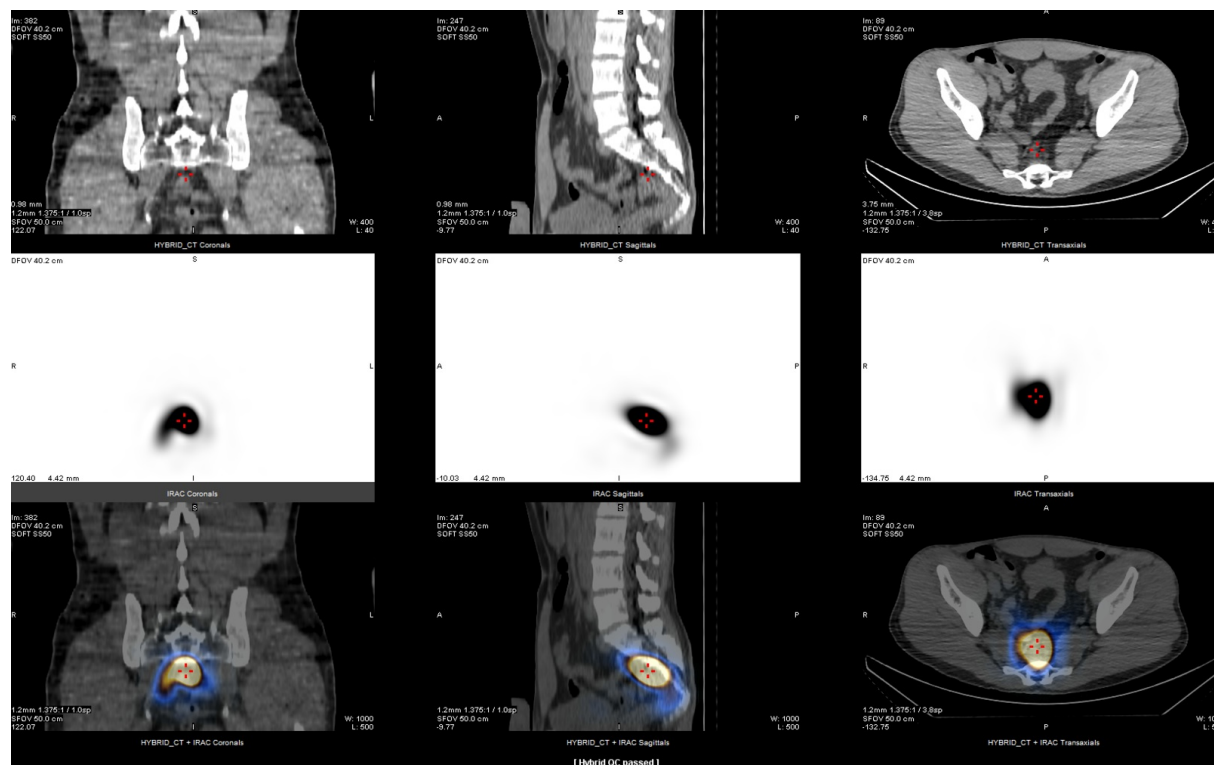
Planar and SPECT-CT imaging over coronal, sagittal and axial planes show no migration of the radioisotope from the injection site in a patient who received an upper rectal injection. The crosshairs highlight focal activity at the injection site.
